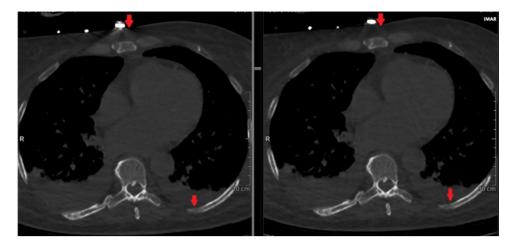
Thoracic CT scan. Left: unreconstructed image. Artifacts are present on the sternum, but none on the ribs. Right: reconstructed MAR image. The artifacts on the sternum disappear, but a new artifact appears on a rib.
